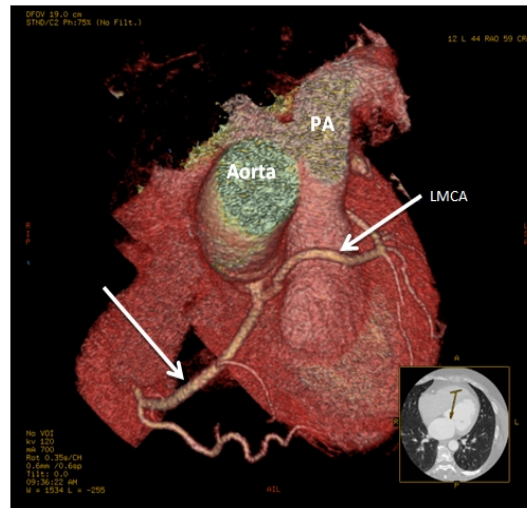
Volume rendering CTA of anomalous LMCA arising from right coronary artery ostium.
